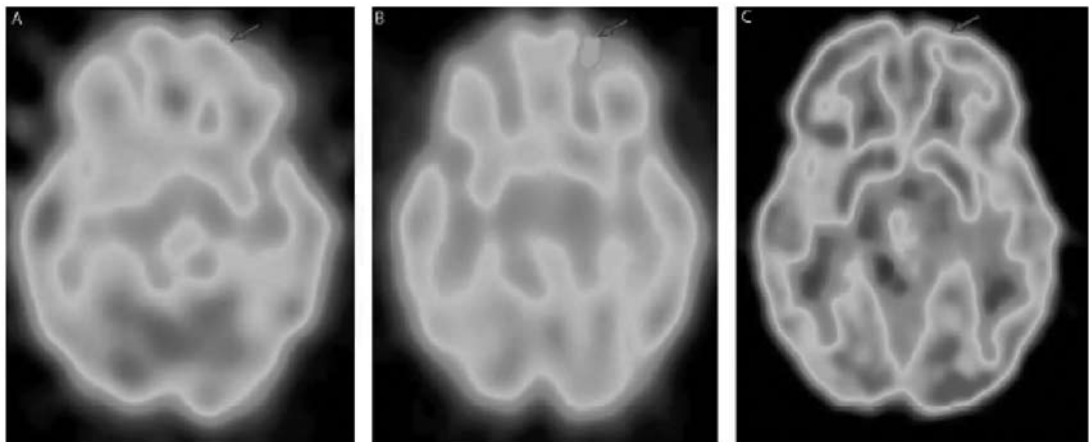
Patient with focal epilepsy in the left frontal lobe. (A) Ictal Tc-99m ECD SPECT. (B) Interictal Tc-99m ECD SPECT. (C) Interictal F-18 FDG PET.⁶
